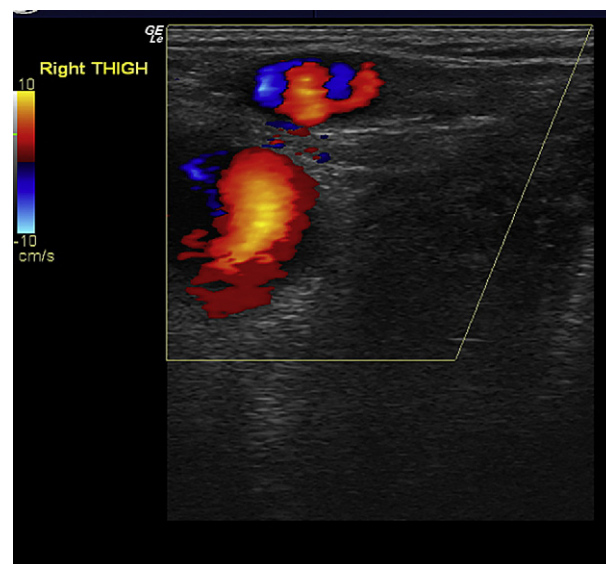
Saphenous varix shows flow on colour Doppler.
